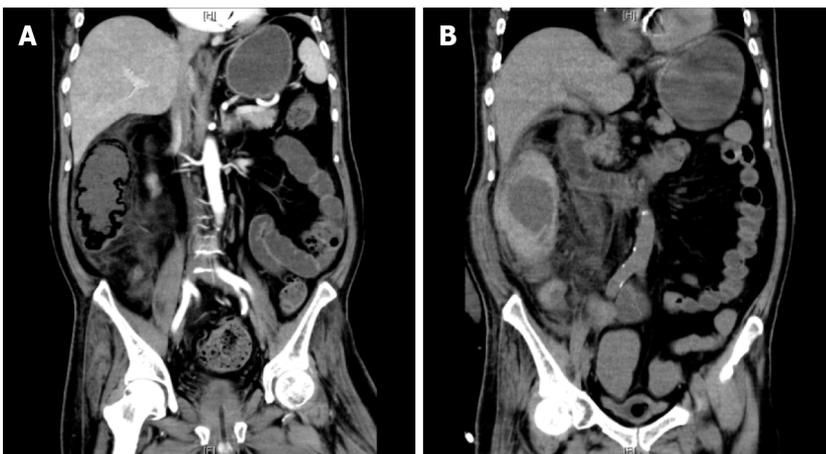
Abdominal computed tomography. A: The initial abdominal computed tomography (CT) showed ascending colon emphysema with fluid planes and exudative changes; B: The second abdominal CT showed thickening of the wall of the ascending colon with multiple exudative changes around it and possible local hematoma.
